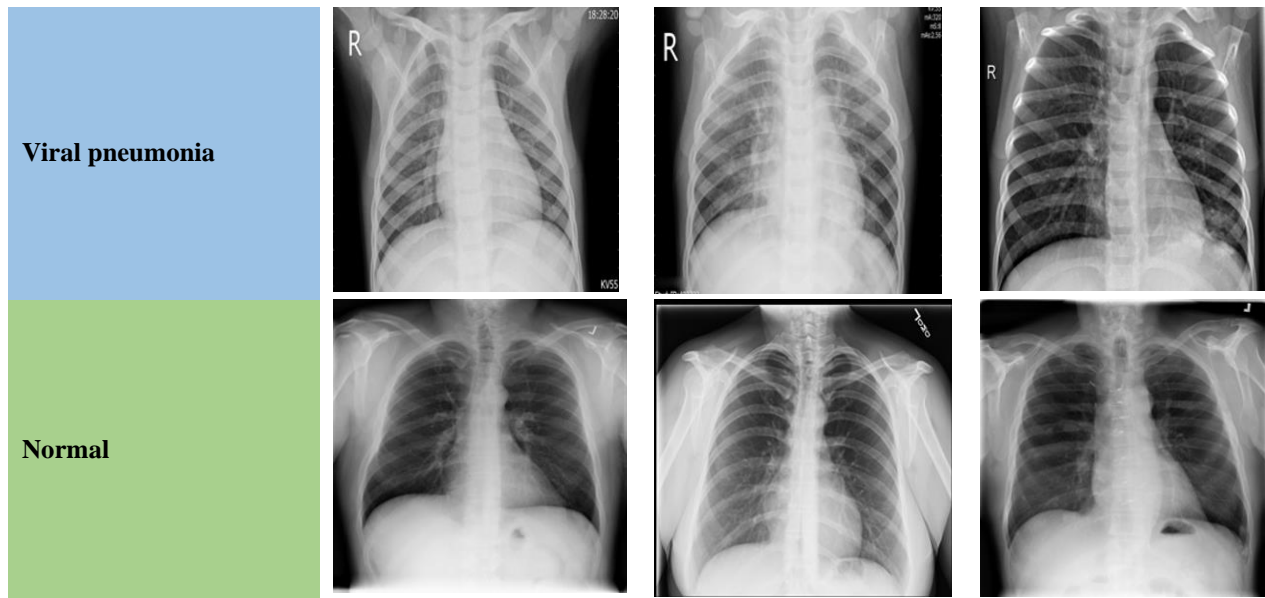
Chest X-ray images of patients with COVID-19 (first row), viral pneumonia (second row), and normal (healthy) individuals (third row).
